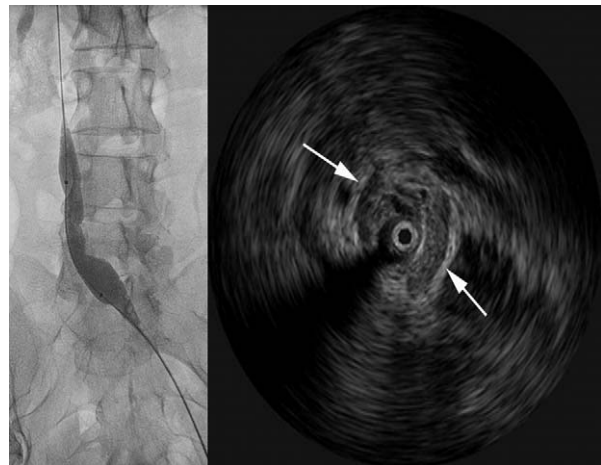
The stenosis/occlusion should be dilated to accommodate a stent of approximately the same size as normal anatomy for proper function (*left*). In rigid lesions and occlusions, overdilation by 1 or 2 mm will allow for recoil. The Glidewire seldom strays outside the occluded vein, and this can be confirmed by intravenous ultrasonography after predilation (*right*). Dilations of up to 24 mm in the inferior vena cava has not resulted in clinical hemorrhage.
